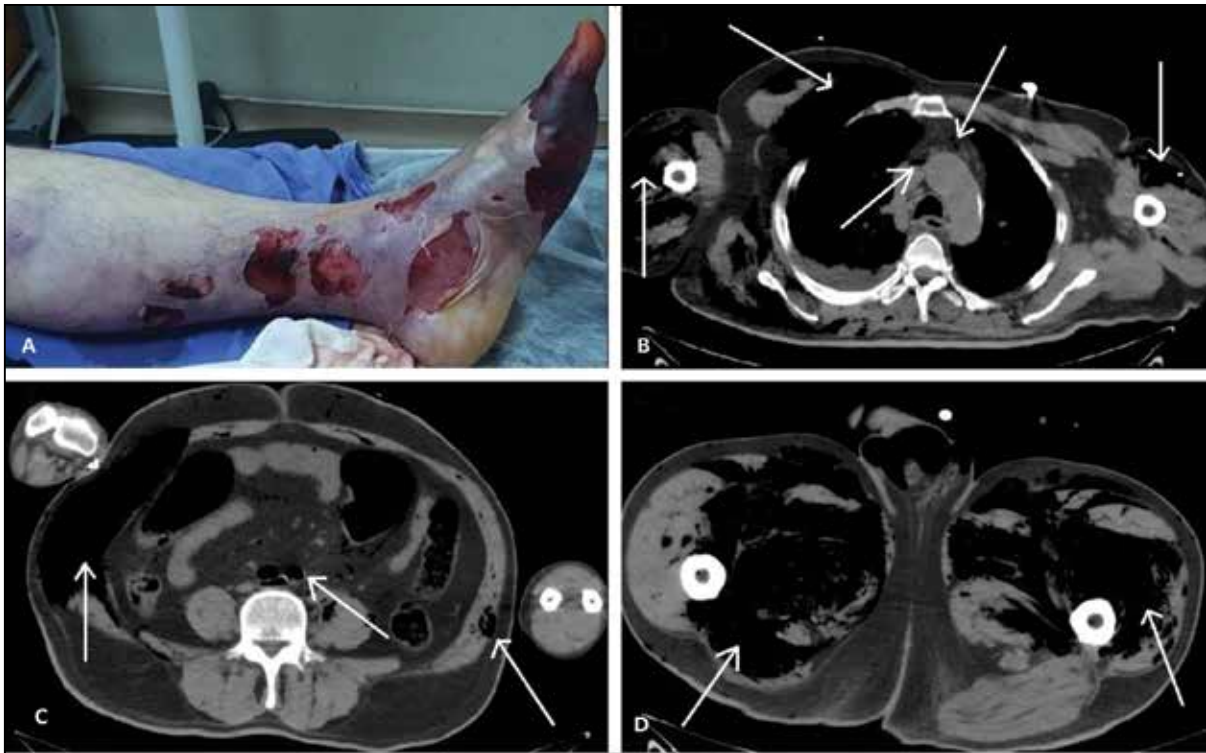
A) Necrotic and ischemic appearance in middle 1/3 and distal left cruris. B) In unenhanced thoracic computed tomography (CT) examination, common air densities and subcutaneous emphysema under the skin and between the muscle planes were observed at both upper extremities and the right half of the thorax wall and common air densities observed at truncus pulmonalis and right ventricle level (white arrows). C) In unenhanced abdomen computed tomography (CT) examination, widespread air densities were observed, extending to the level of the pelvis and more prominent on the right side in both halves of the abdominal wall and linear air densities were observed between mesenteric fat planes and mesenteric vascular structures (white arrows). D) In pelvis and left lower extremity computed tomography (CT) examination, common air densities and subcutaneous emphysema were observed throughout the subcutaneous tissue and muscle planes in all segments of the left lower extremity (white arrows).
